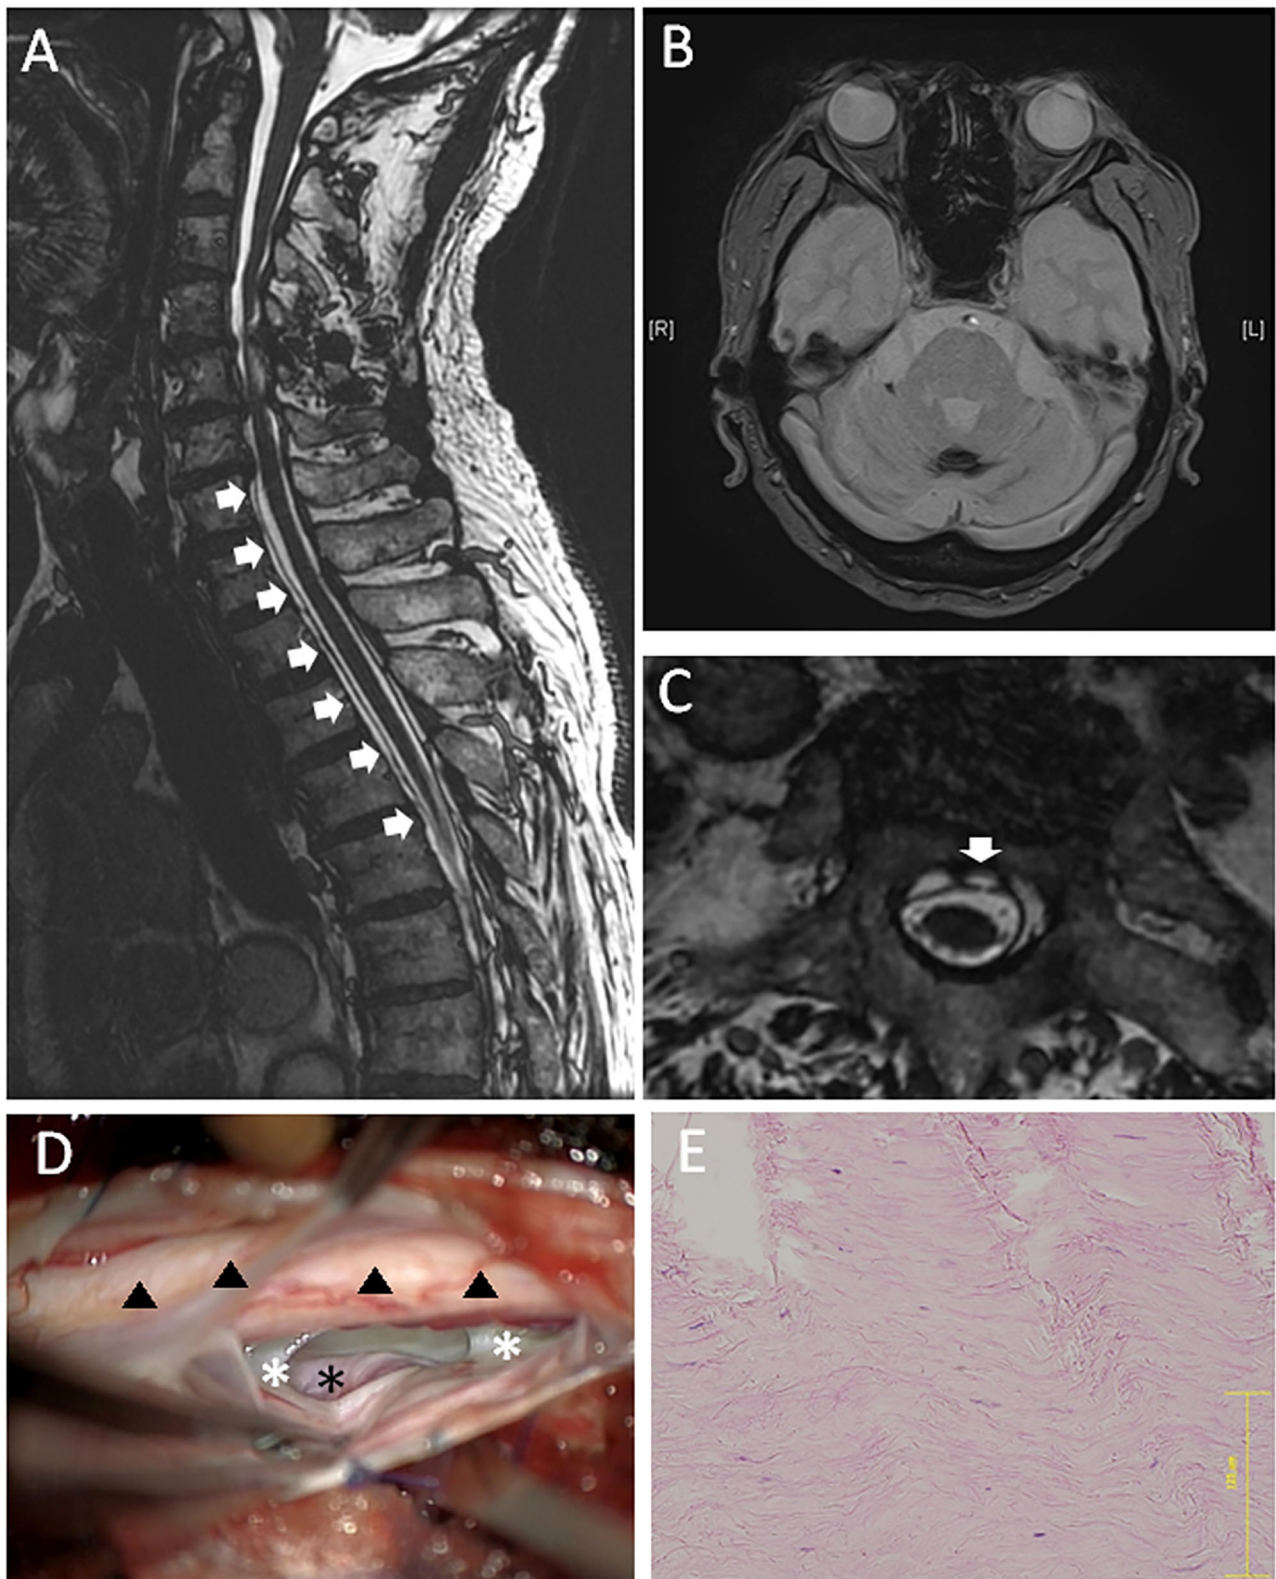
A 79-year-old male (case 3). (A) Sagittal MRI showed VFCC from C7 to T7 in the spinal canal (white arrows). (B) Brain MRI showed a hemosiderin deposition at the sulcus. (C) An axial FIESTA image at the T2 level demonstrated a defect located at the left paramedian anterior dura (the white arrow). (D) An
